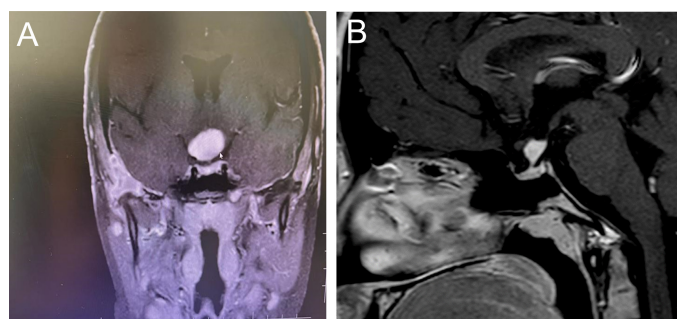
Pituitary magnetic resonance imaging at diagnosis and before chemotherapy (A, coronal slice; B, sagittal slice).
